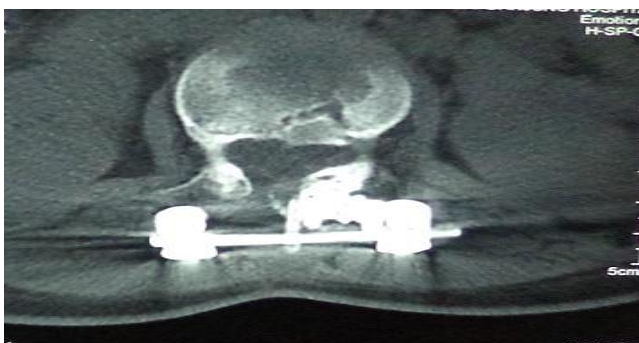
Sagittal section (1.5.1,1.5.2) and axial section CT Scan after 24 weeks showing fusion mass
